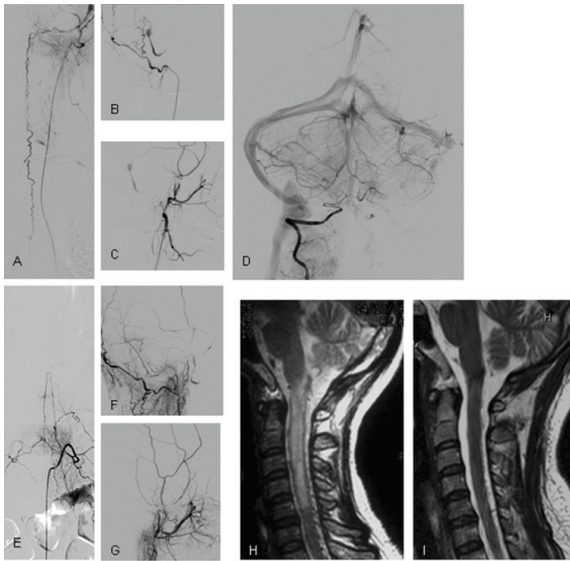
A 37-year-old female had progressive right-sided paresthesia and left-sided weakness for 6 months. (A) Frontal view of occipital artery injection, (B, C) lateral views of left occipital and left internal maxillary arteries injection, revealed dAVF at left transverse-sigmoid junction with draining into posterior spinal veins. (D) Frontal view of right vertebral artery injection revealed thrombosis of left sigmoid sinus. (E) Frontal view of normal radiculomedullary artery was arising from intercostal artery of left T12 level. (F, G) Lateral views of occipital and internal maxillary arteries injection revealed completed obliteration of shunt after glue embolization. However, patient had not recovered from those symptoms. (H) Preoperative MRI showed abnormal signal changes on T2W at cervicomedullary junction to C5 level with multiple flow voids posteriorly. (I) Post treatment MRI showed reversible high signal intensity of spinal cord and diminished flow voids. However, the image was not corresponding to the clinical outcome.
